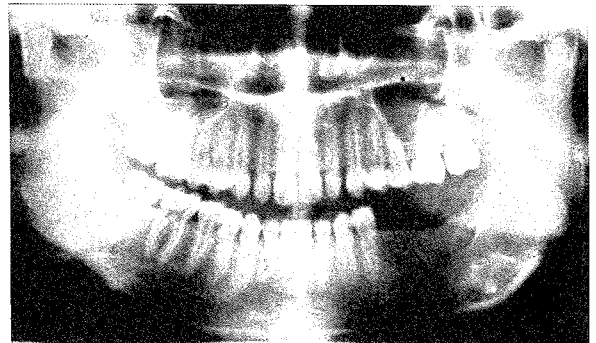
14 months post-operative panoramic radiograph showing complete bony healing in the region of the mandible from which the ameloblastoma was removed (Case 1).
